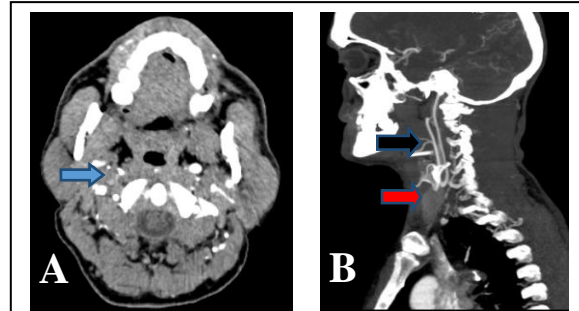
A-The axial slice in front of c1 shows very poor flow in right internal carotid artery (blue arrow) indicating thrombosis. B-The sagittal view of CT angiography of cervical arteries shows poor blood flow in both internal and external carotid arteries (black arrow) and occlusion in common carotid (red arrow).
